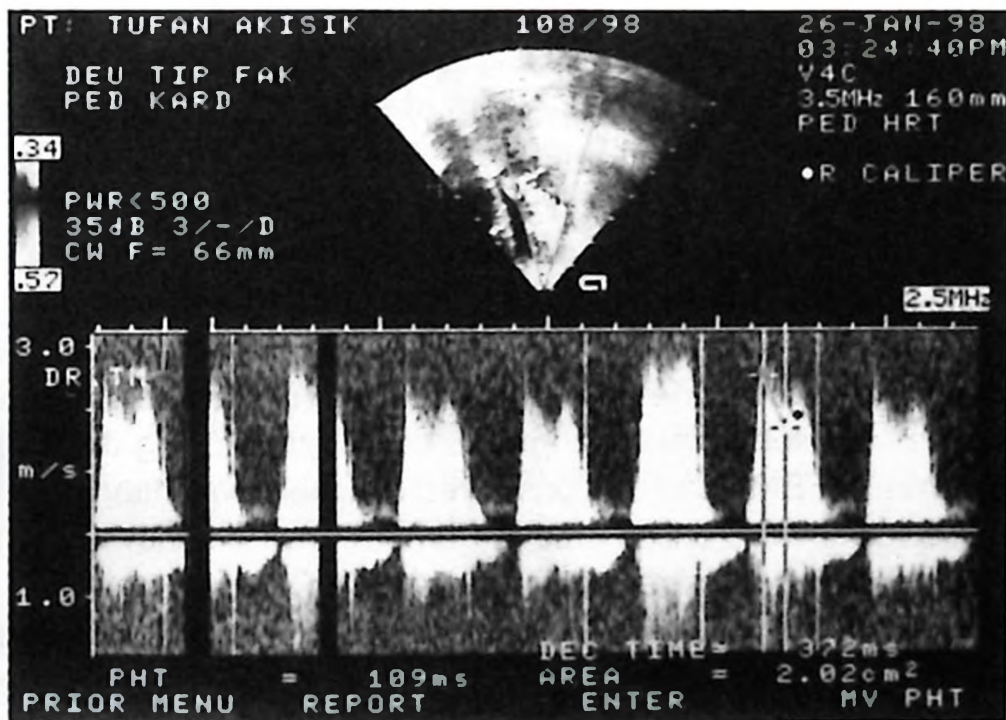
Transmitral gradients measured by echocardiography.
